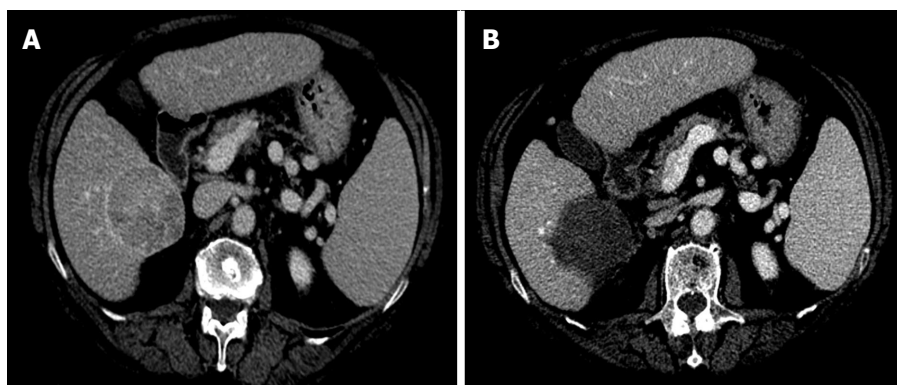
Representative case of complete ablation of large nodule with multi-fibre technique. A: Computed tomography (CT) scan before laser ablation (LA) session shows a nodular lesion 6 cm in maximum diameter (hepatocellular carcinoma moderately differentiated) localized in the S6 with exophytic growth (exophytic component > 40%); B: CT scan performed 4 wk after LA procedure shows complete necrosis of the tumor. Four illuminations were performed using the pullback technique and the treatment lasted 24 min. The procedure was well tolerated and the patient was discharged from the hospital 24 h after the procedure. The only side effects were mild pain and self-limiting fever lasting for 7 d.
